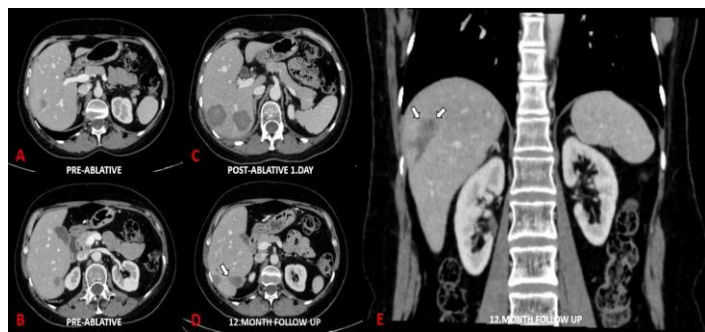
46-years-old female patient with liver metastases of breast cancer. There are two metastatic lesions located in segment 6 (A and B). Computed tomography (CT) image on the first day after microwave ablation showed the ablation zones with no evidence of residual tumor(C). But in 12th month control, axial (D) and coronal (E) CT images demonstrated the local recurrence. Nodular shaped LR at the entry zone of ablation tract with noncapsular site localisation (white arrow in D) and nodular shaped LR at the side zone of ablation tract with capsular site localisation (white arrows in E).
